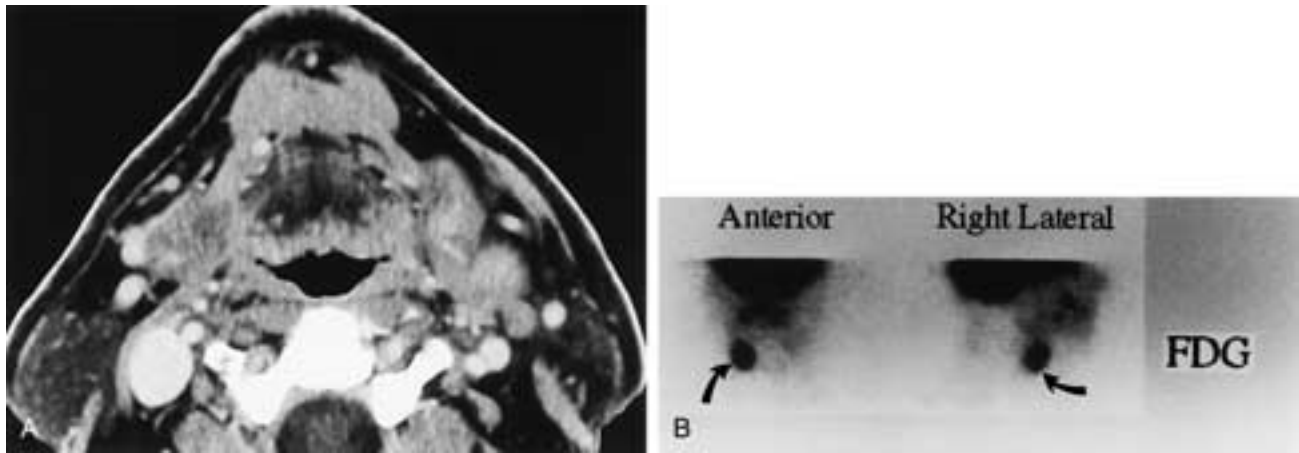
A, Axial CT scan from a contrast-enhanced study demonstrates a normal-appearing tongue base. B, FDG images show a focus of abnormal uptake in the tongue base (arrows). Biopsies of this area showed squamous cell carcinoma.
